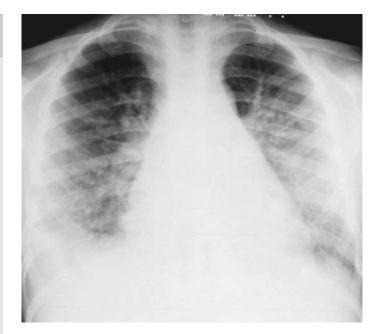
Chest X-ray of a patient with poststreptococcal glomerulonephritis showing pulmonary edema.
